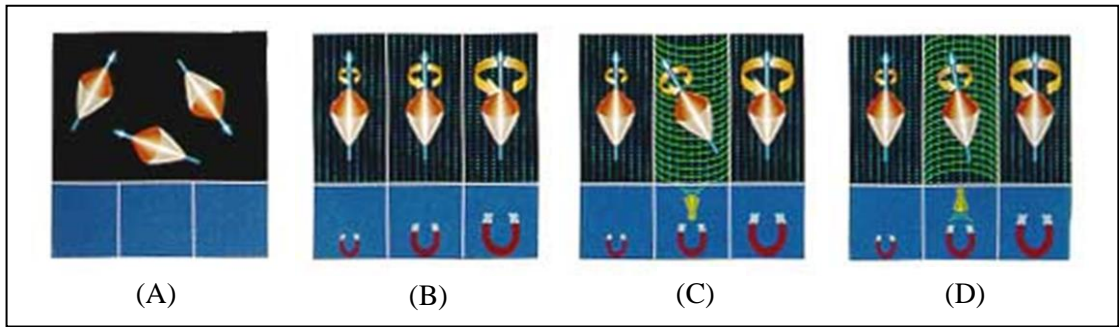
The way MRI works: (A) Hydrogen protons, (B) Hydrogen protons exposed to magnetic field, (C) Hitting proton by radio wave, (D) Proton returning to its original orientation after stopping the radio wave. Derived from (90).
